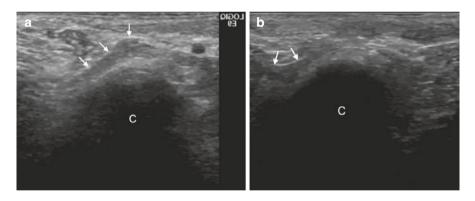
Sagittal transoral sonographic imaging of the TMJ in an asymptomatic volunteer in the closed-mouth position (a) The condyle (C) and the posterior band and thin zone of the disc (arrows) are in a normal anatomic position. (b) The anterior disc band (arrows) is shown along the anterior condylar surface. C condyle
